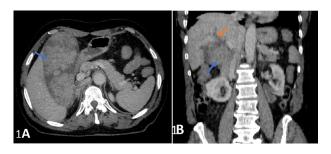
Abdominal CT scan in axial (A) and coronal (B) section with injection of contrast shows a distended gallbladder with polypoid formations of tissue density (blue arrow), associated with a slight dilation of the intrahepatic bile ducts (orange arrow). Color version of figure is available online.
